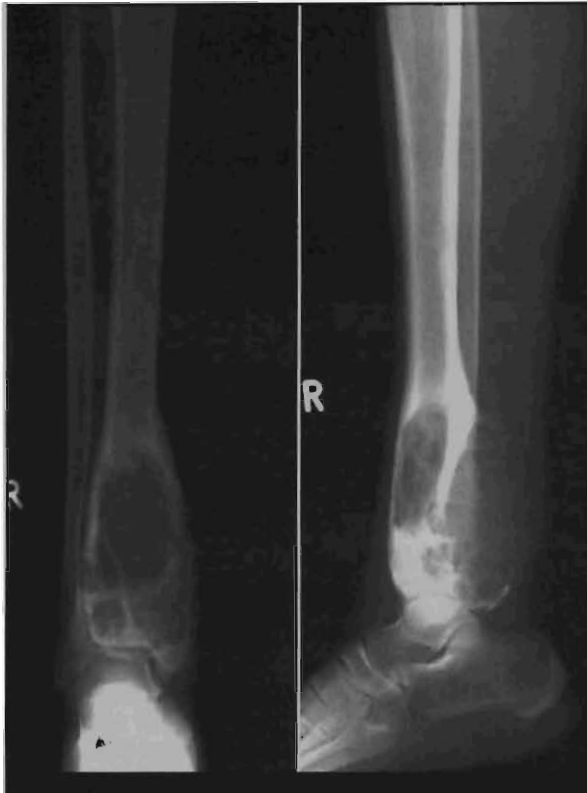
Frontal and lateral X-ray views of the right distal tibia, fibula and ankle demonstrate an eccentric, lobulated, expansile lesion with an ovoid shape and radiolucent centre. Note that the long axis of the lesion corresponds to the long axis of the host bone.
